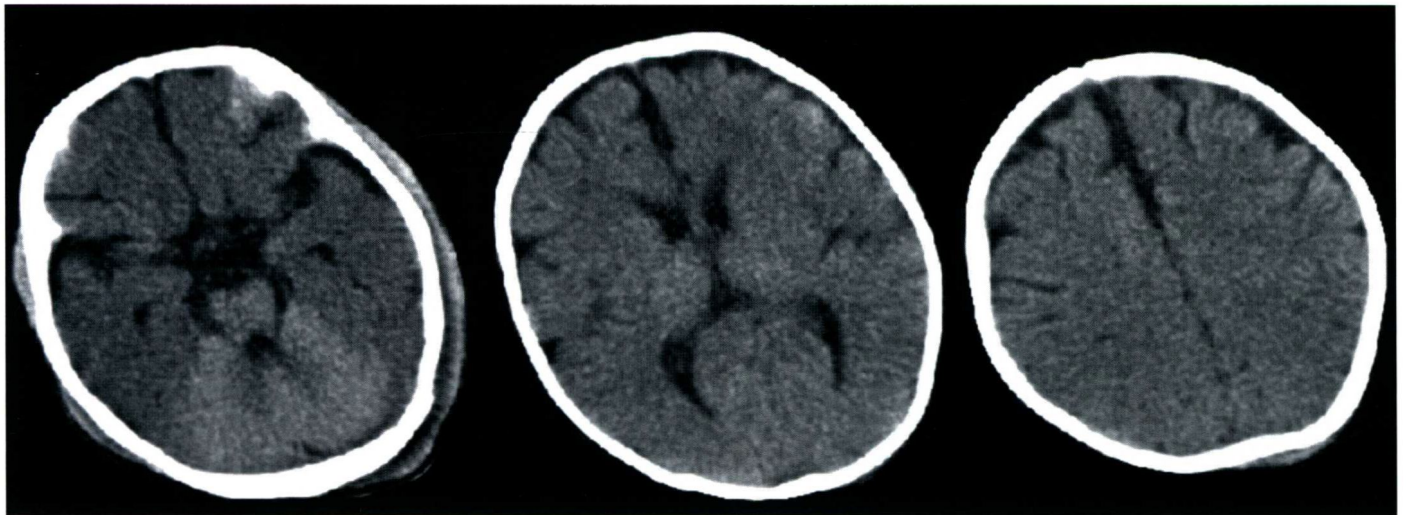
Axial CT images show diffuse loss of gray/white differentiation throughout the supratentorial brain compatible with global anoxic injury. Note the attenuation of the cerebellum, which appears prominent relative to diffusely decreased attenuation of the brain. This is the "white cerebellum sign." Similar differences are observed on MRI, in particular in DWI images.
